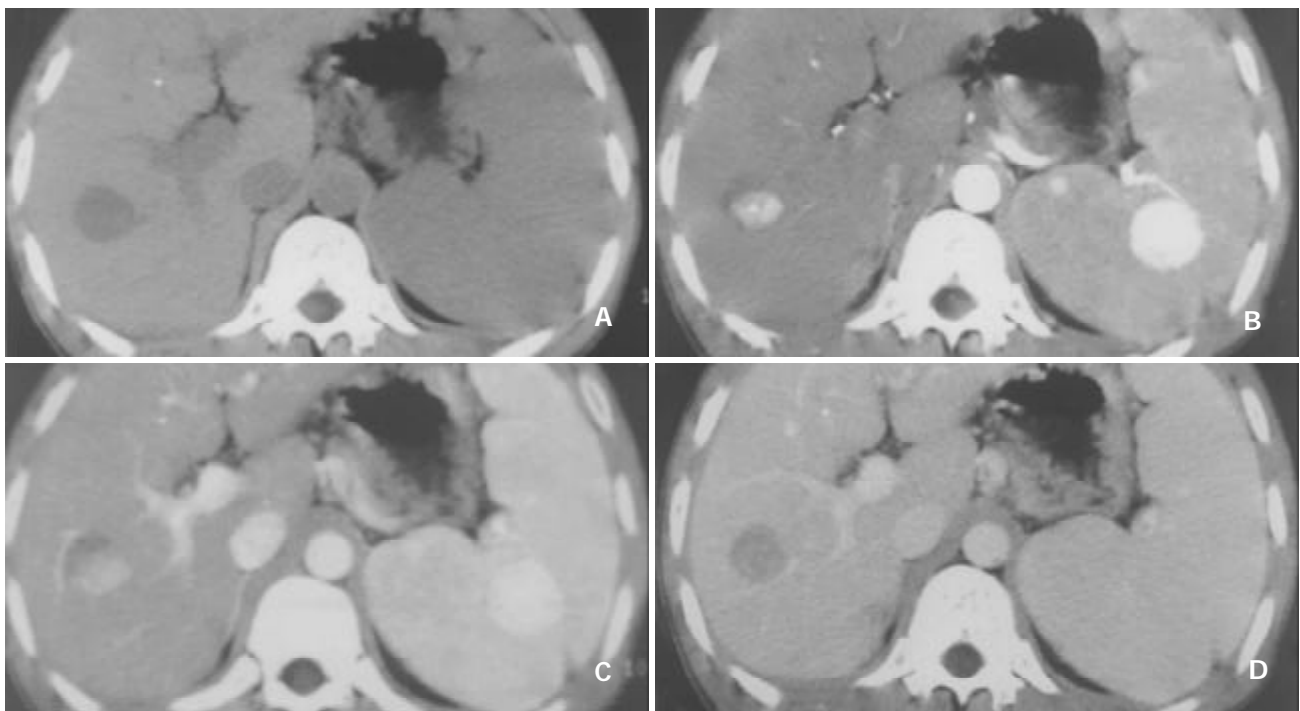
SHCC of 2.0 cm in diameter, A: Precontrast image shows hypoattenuating lesion. B: CT scan obtained at the same level as in the early arterial phase, Tumor intensely enhanced. C: In the late arterial phase, the lesions showed enhancement yet. D: In the portal venous phase, the lesions enhancement dropped down.
